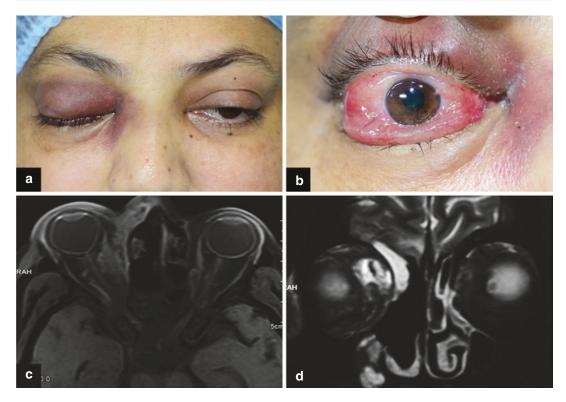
Stage 3c ROCM (a) Clinical picture showing right eye ptosis, periocular edema, and ecchymosis. (b) Severe conjunctival congestion and chemosis. (c) Axial MRI (T1) of orbit and paranasal sinuses showing diffuse orbital involvement along with diffuse paranasal sinus
